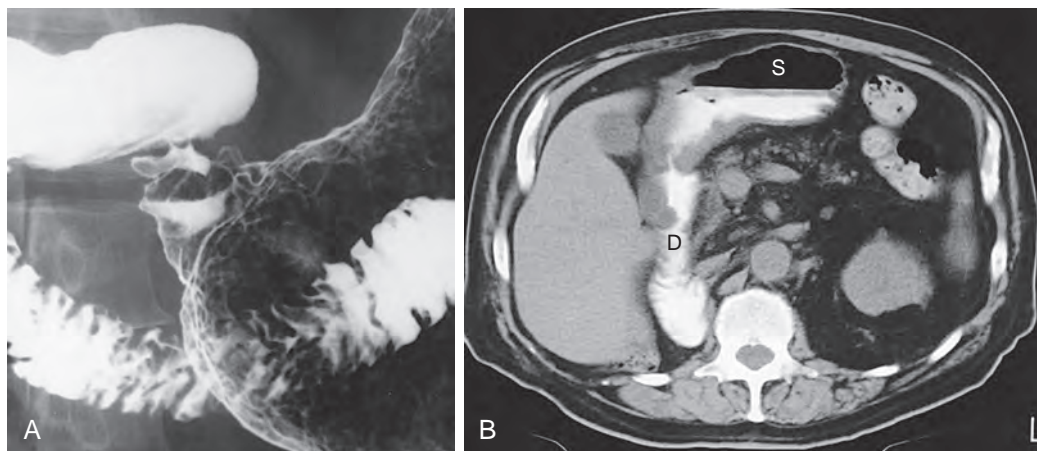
Transpyloric spread of lymphoma into the duodenum. A. Barium study shows nodularity and deformity of the distal antrum and pyloric region caused by gastric lymphoma. The duodenal bulb appears normal. B. CT scan reveals a lymphomatous mass extending from the distal antrum into the proximal duodenum. Even in retrospect, duodenal involvement is not seen on the barium study. D, duodenum; S, stomach. (Courtesy Edward Lubat, MD, Ridgewood, NJ.)
